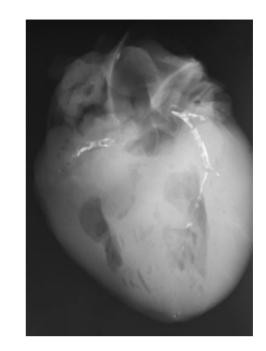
Calcification of all three major epicardial arteries in a postmortem radiograph of the heart.
